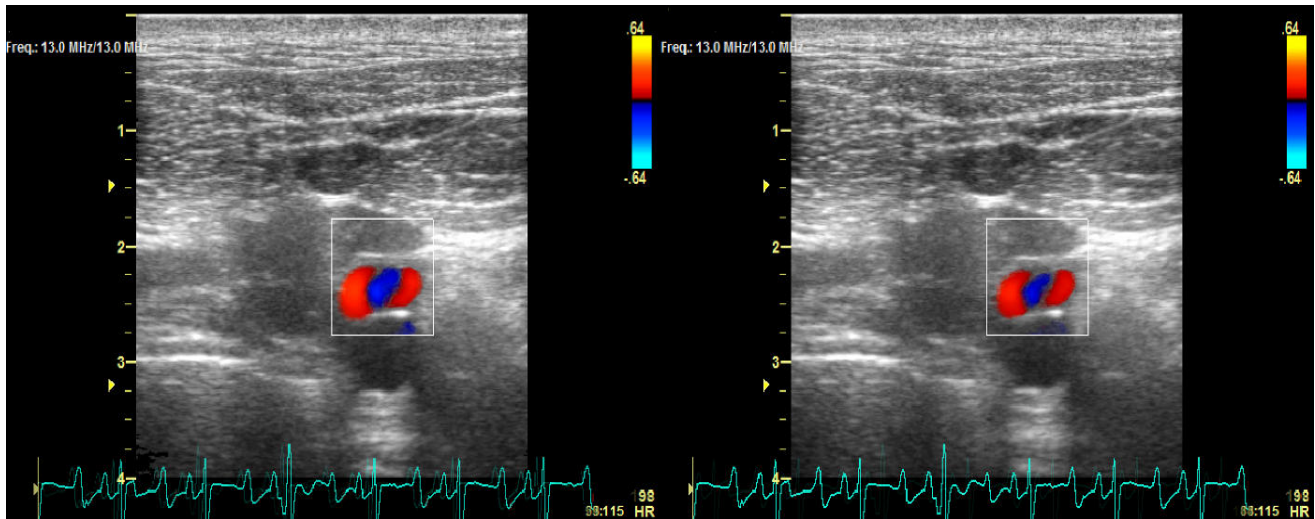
Dean vortices at cross-sections obtained transectaneously by color Doppler ultrasound. The color demonstrates the direction of the velocity components which are parallel to the view plane. The red color exhibits flow towards, whereas blue flow away from the probe. Maximum inlet flow rate (left); Minimum inlet flow rate (right).
